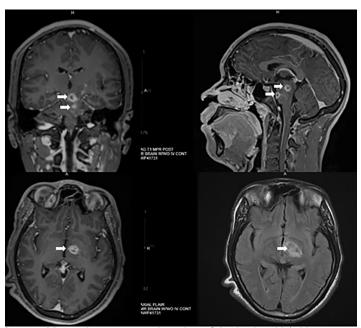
Magnetic resonance imaging of the brain with/without intravenous contrast: multifocal abnormal enhancing lesions (white arrows) in the bilateral cerebral hemispheres, left thalamus, and brainstem.
